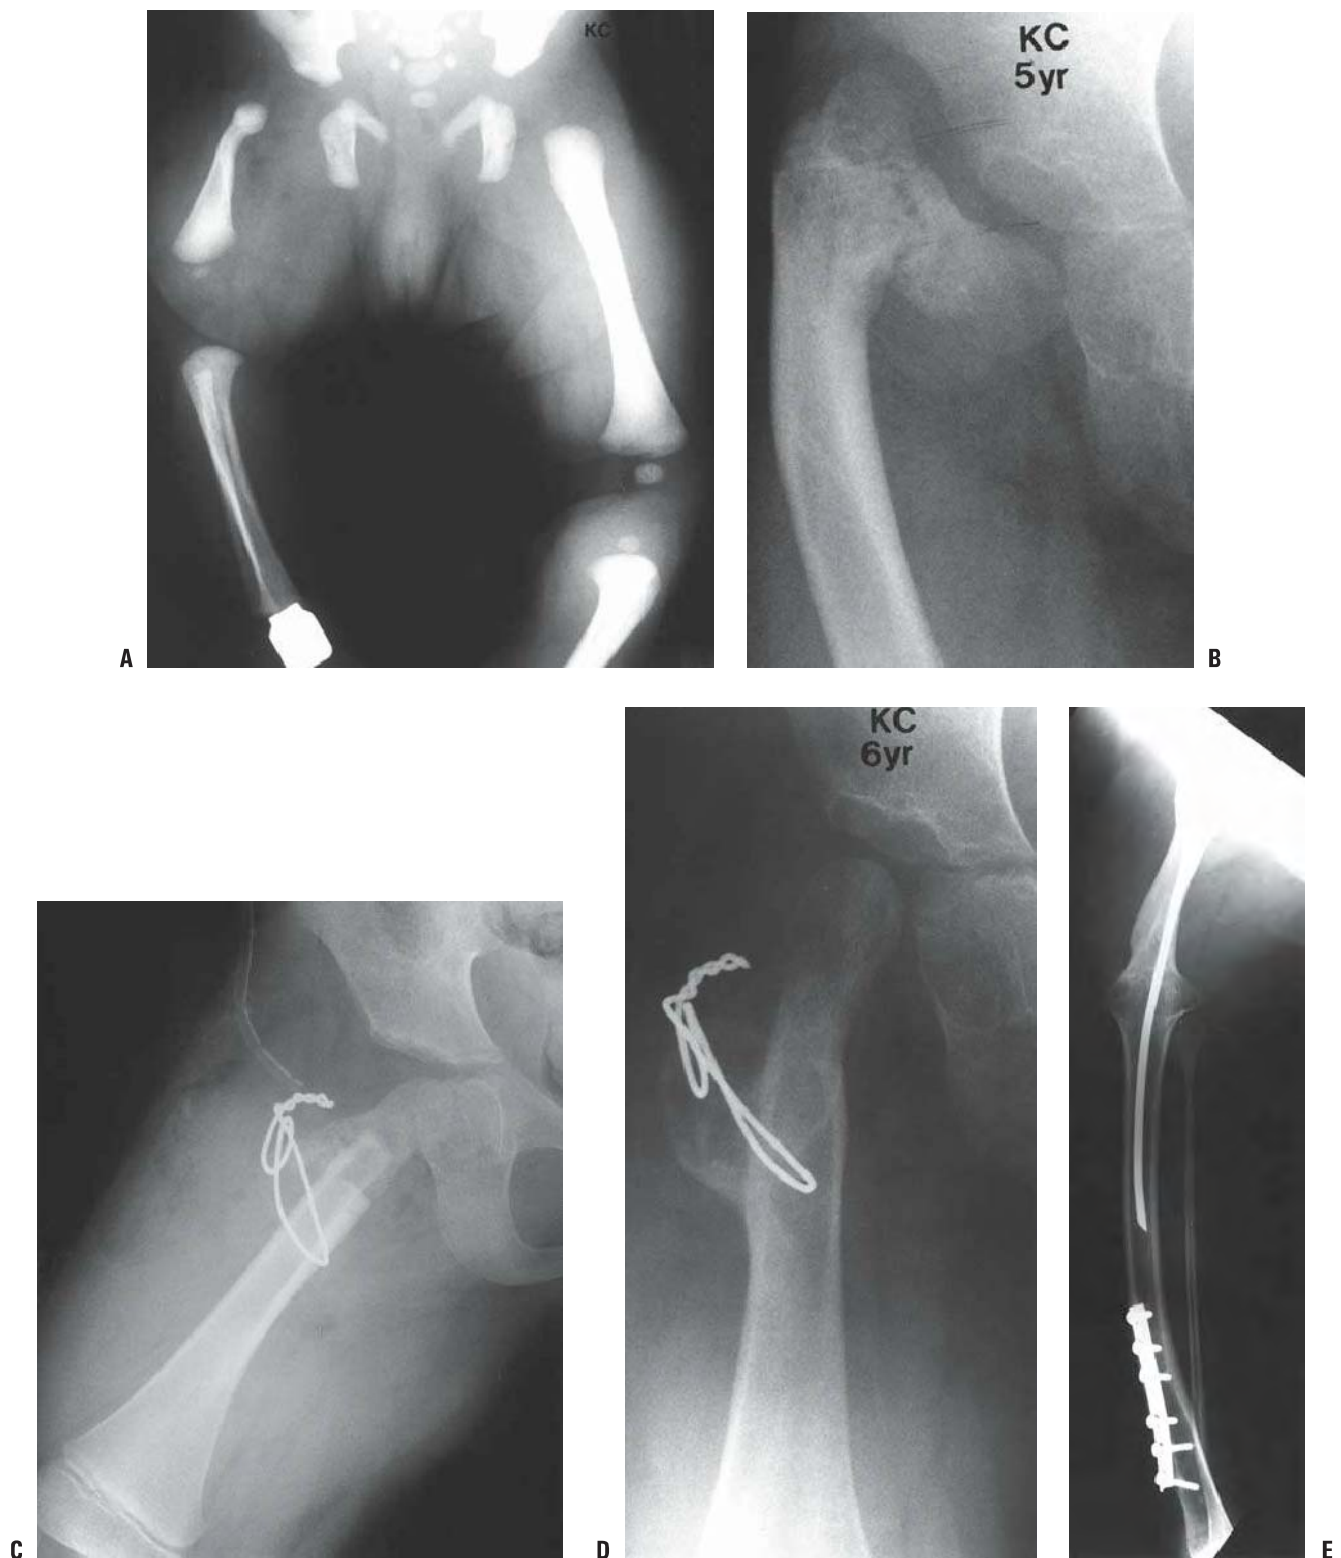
A: AP radiograph of the pelvis and limbs of a newborn girl with Aitken class B PFFD. Note the short femoral segment and the well-developed acetabulum, although the femoral head is not visible. B: By 5 years of age, the femoral head is ossified and the cartilaginous connection between the femoral head and the subtrochanteric region of the femur has undergone considerable ossification. However, a pseudarthrosis persists and a significant varus deformity has developed. C: The femur after correction of the varus with a spike type of osteotomy. D: The result 1 year later. Now faced with a projected discrepancy of 20 cm, the parents elect a Van Nes rotationplasty. This was done with part of the rotation through the knee arthrodesis, and the remainder through the tibia. E: The radiographic result. The patient had one additional derotation performed through the midtibia at the age of 10 years.
